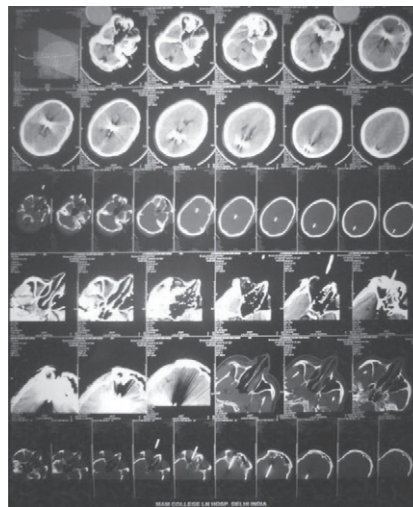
Preoperative CT Brain with Orbit
